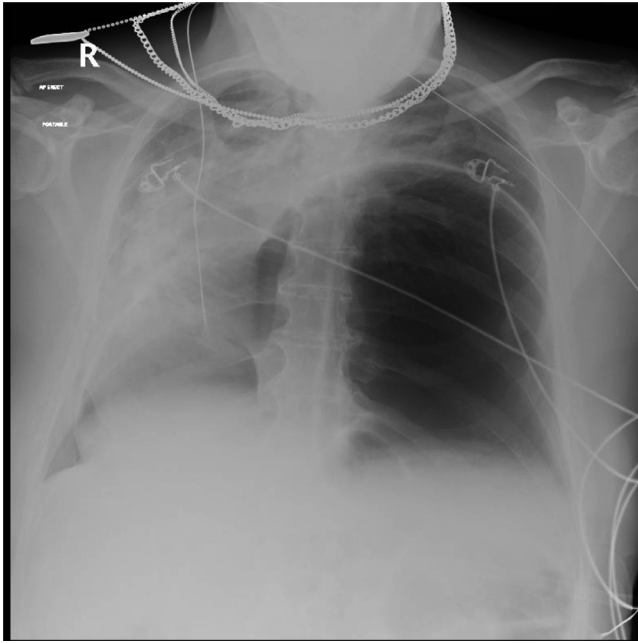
Chest roentgenogram showing gastric air bubble in left hemithorax with mediastinal shift to the right side.
